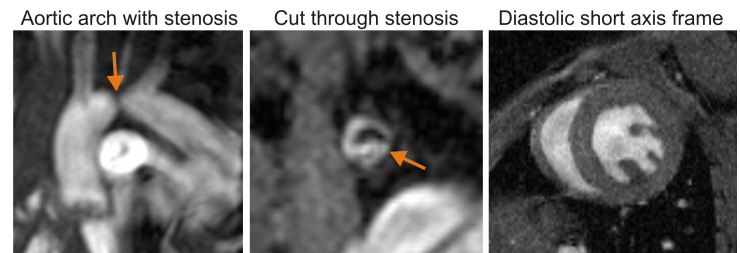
MR images showing the aortic arch after the creation of the stenosis (left, arrow). A transversal imaging plane through the stenosis showed some signal voids due to the accelerated and complex stenotic blood flow (mid). Right: a short axis frame during diastole shows a mild hypertrophy of the left ventricle.
